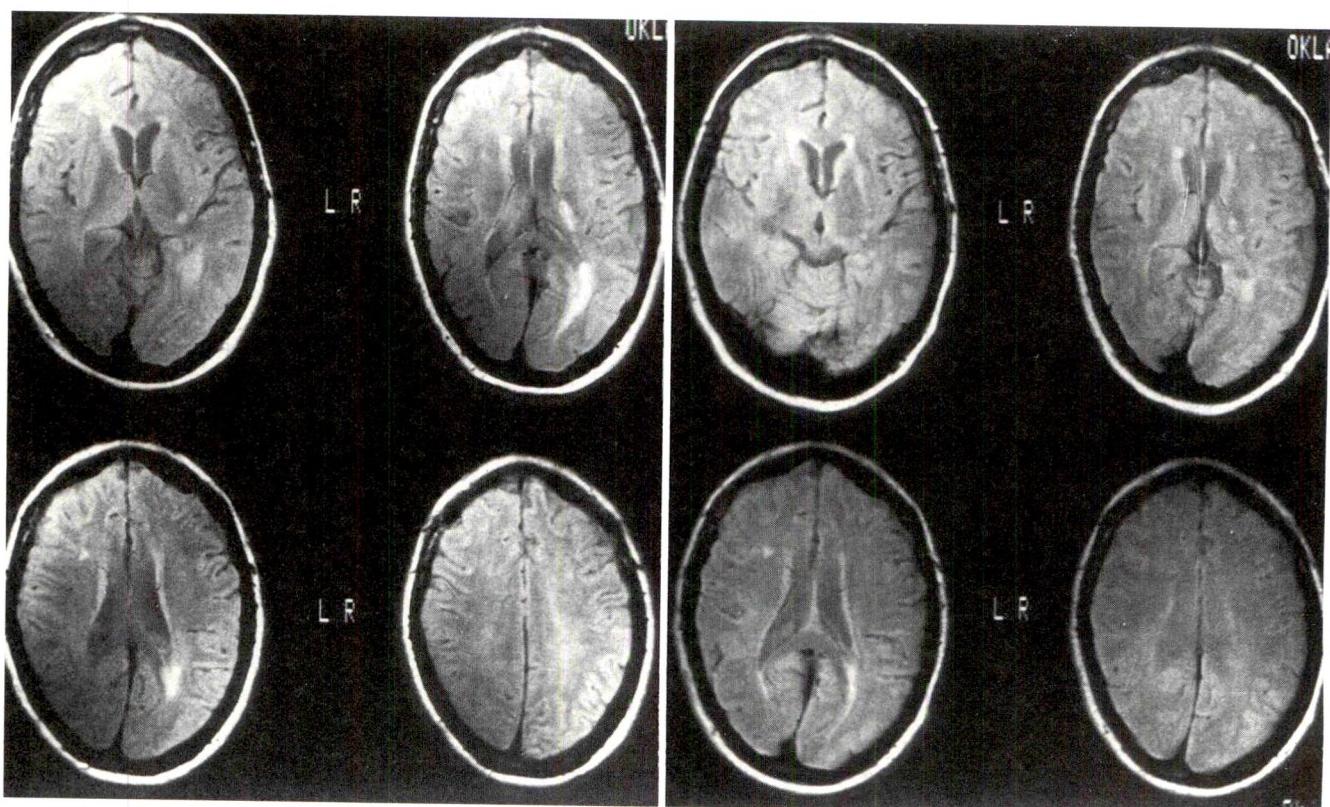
(left). Magnetic resonance imaging (MRI) obtained after patient exhibited focal neurological symptoms. Present are abscess in both the left optic radiation and the internal capsule. (right). Follow-up MRI showing resolution of abscesses. The patient was free of the limitation of upward and lateral gaze and the right upper extremity weakness that had prompted the initial MRI.
